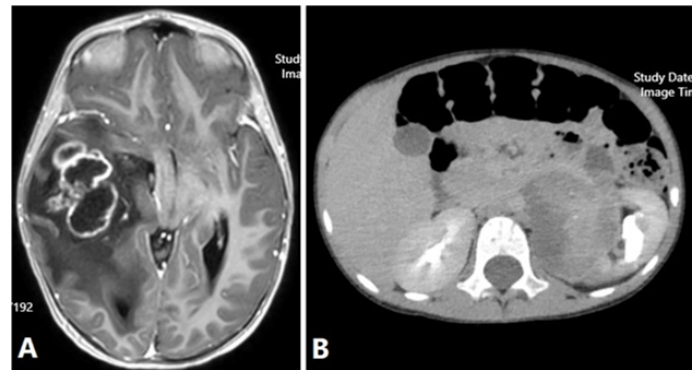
(A) MRI showed a multicystic mass of the right parietotemporal lobe measuring 60*41*38mm with peripheral wall enhancement and peripheral angiogenic edema. (B) Abdominal computed tomography (CT) scan detected a calcified mass arising from the left adrenal.
